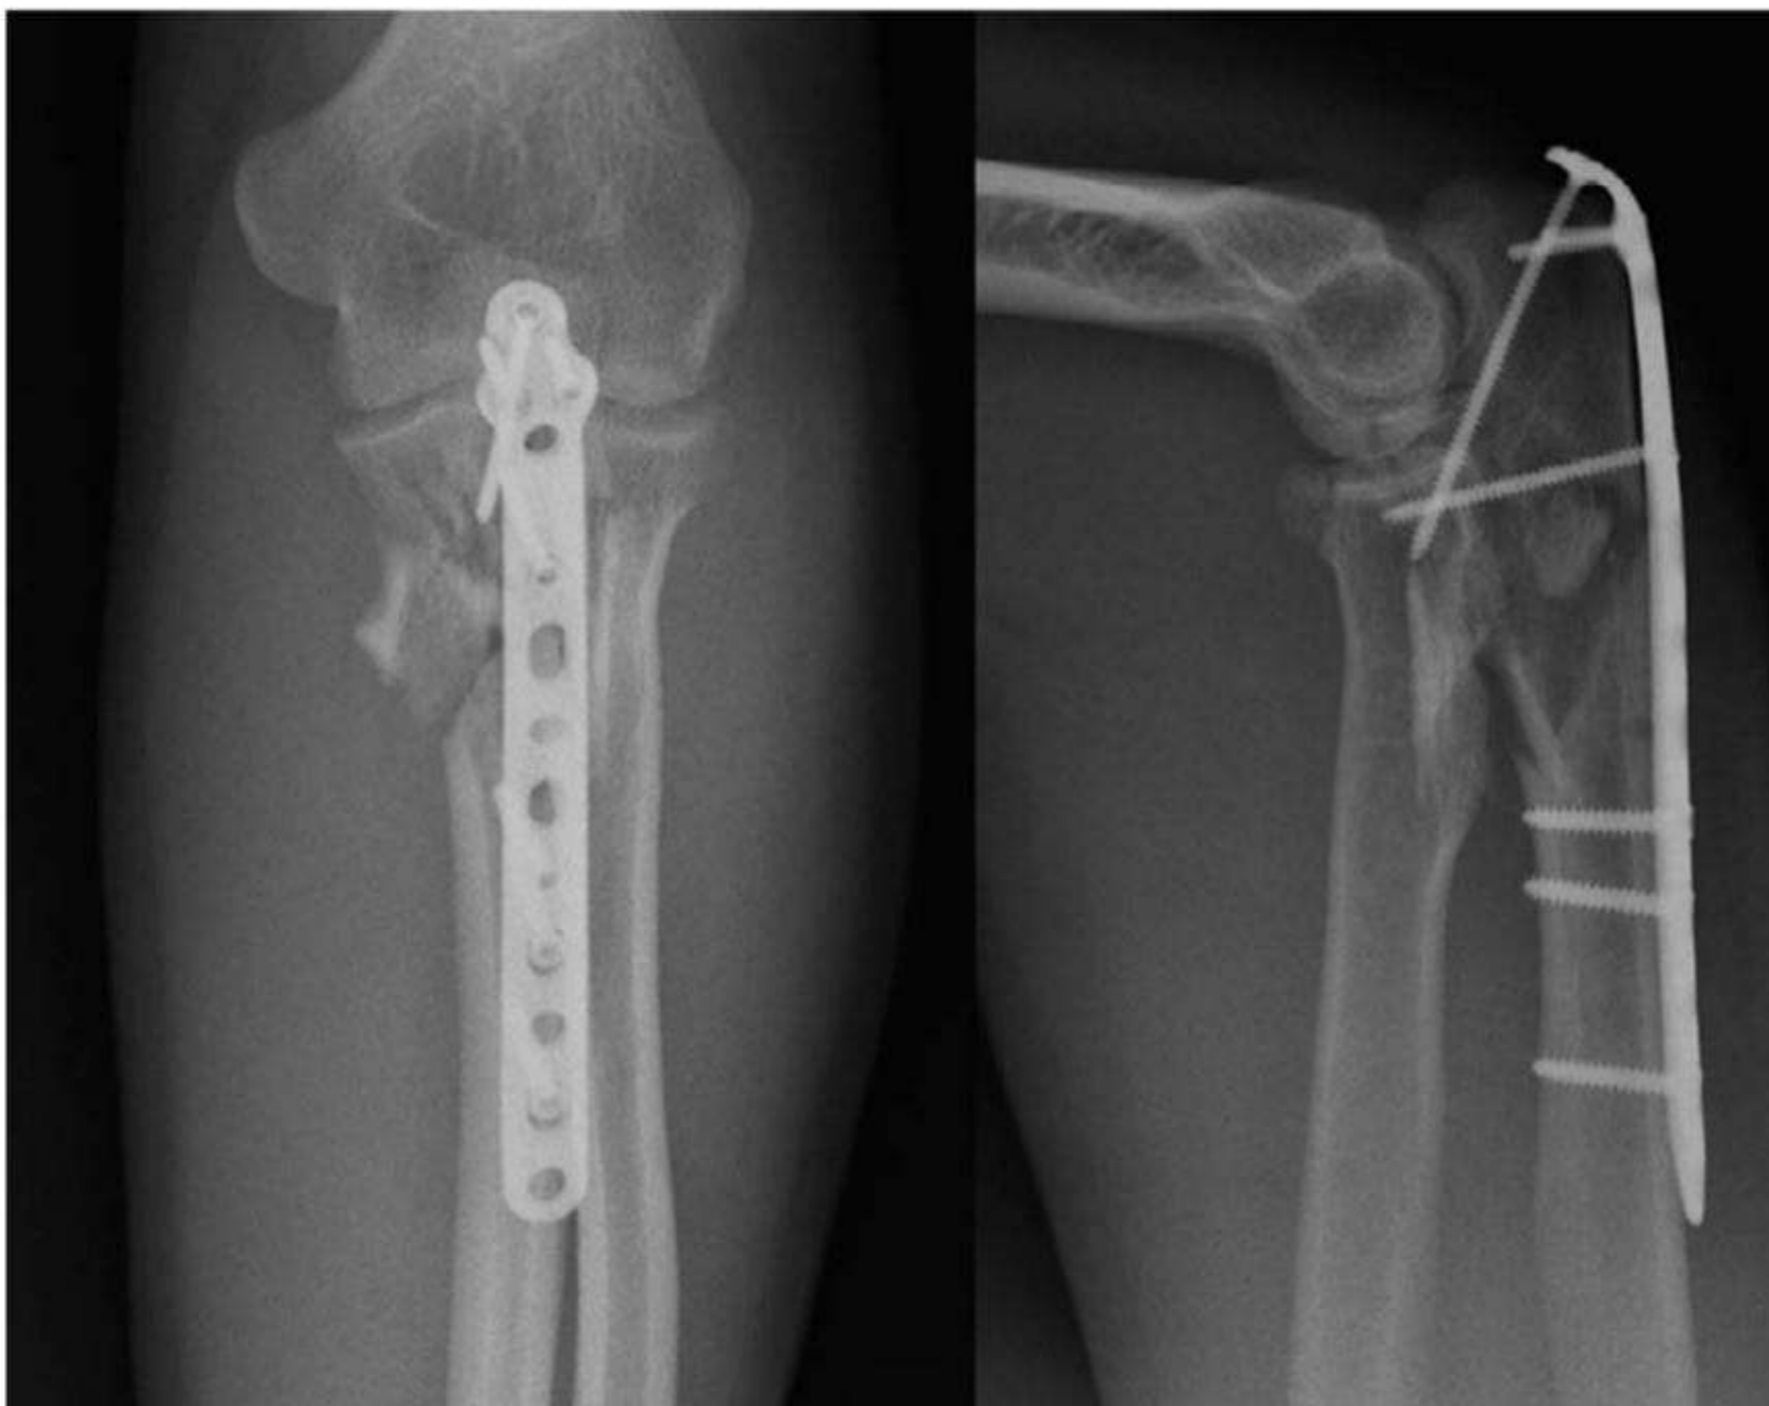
Anteroposterior (AP) and lateral radiographs right elbow post-fixation.
